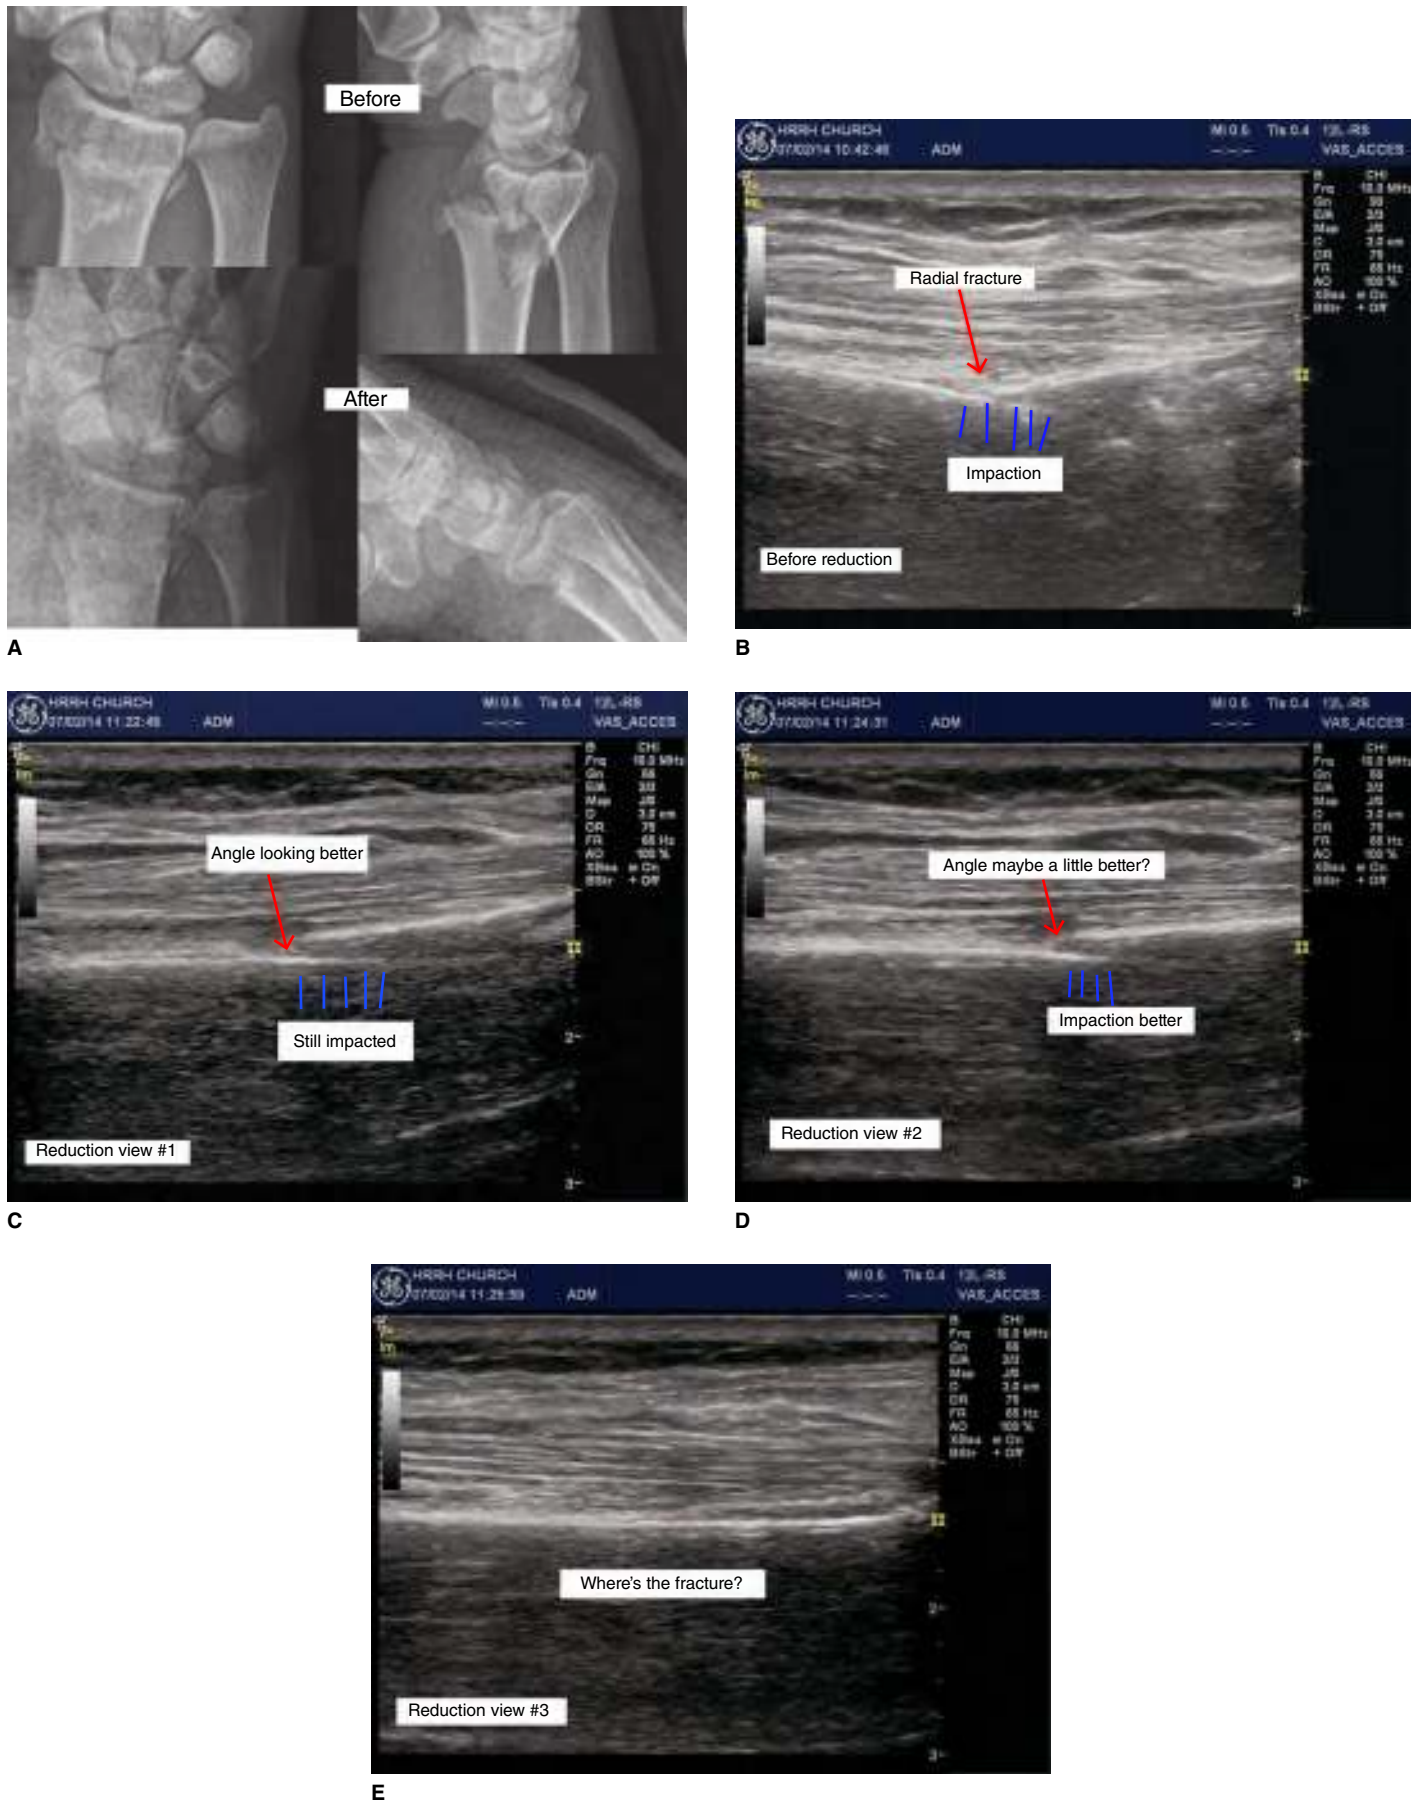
US reduction of a Colles fracture. A. Radiograph. B. Initial US. C. First reduction. D. Second reduction. E. Third and final reduction. (Photos courtesy of Lloyd Gordon, MD.)
